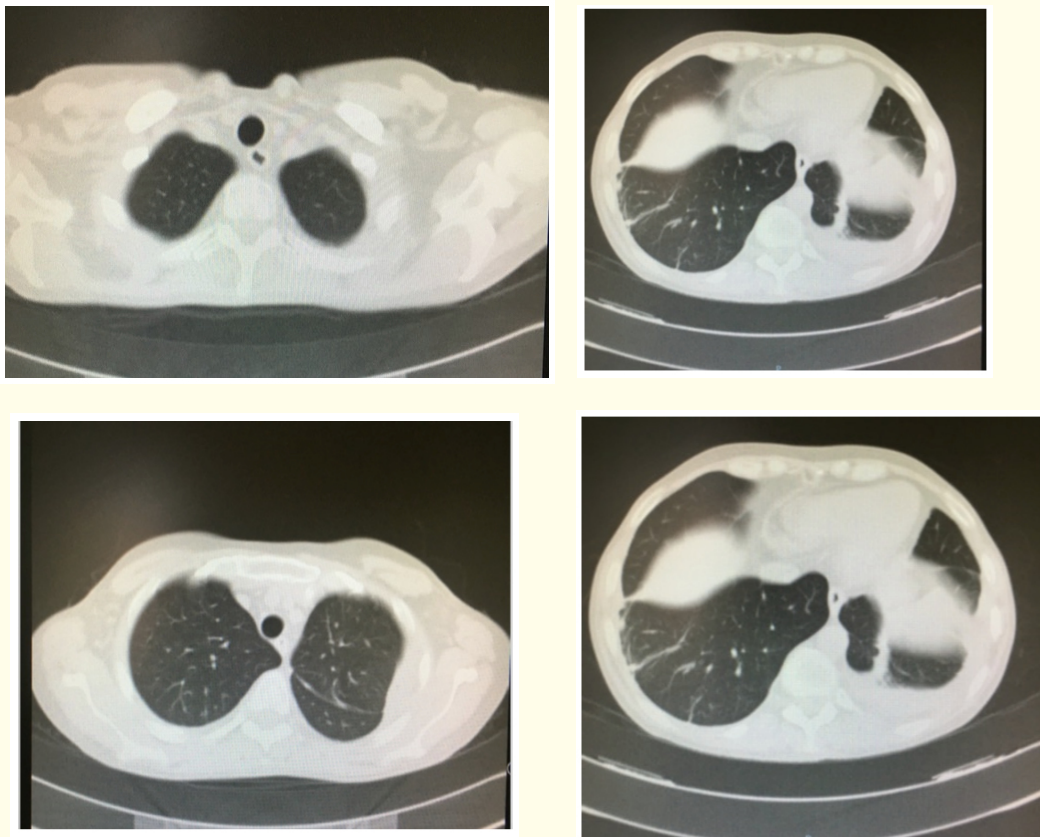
Chest CT on discharge.
